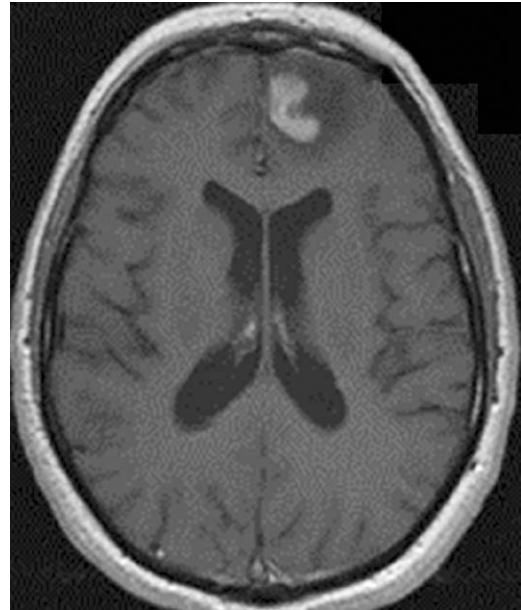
T1 MRI of the brain with contrast demonstrating a single homogeneously enhancing mass in the left frontal lobe.
